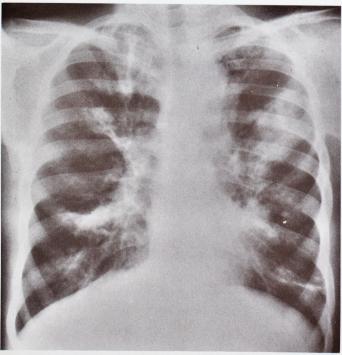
A posteroanterior chest radiograph of a patient with allergic bronchopulmonary aspergillosis demonstrates dramatic bilateral disease. Abnormal densities radiate from the hilar regions, and Y-shaped branching shadows are seen at the midportion of the lungs.
